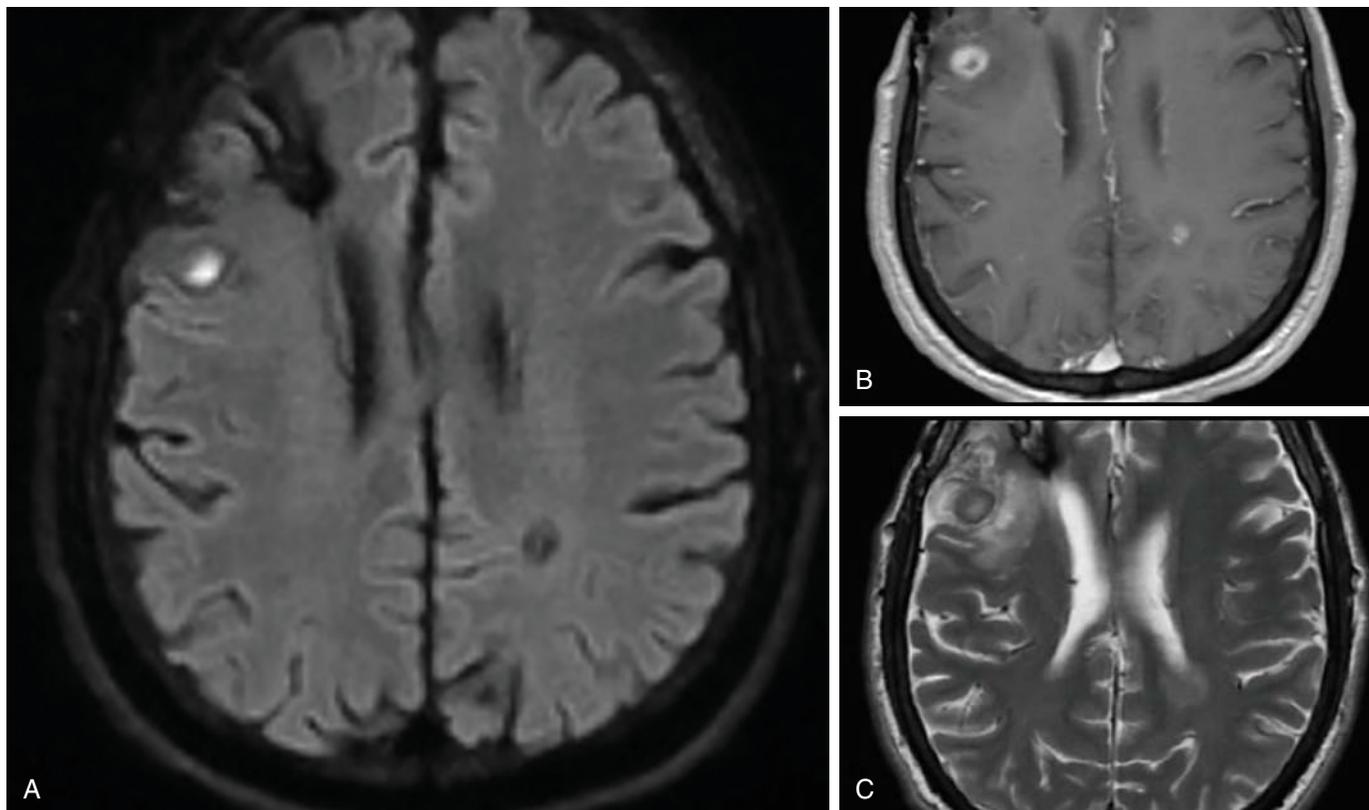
Cerebral abscess. A, Diffusion-weighted image shows a round lesion in the right frontal lobe with central hyperintensity representing restricted diffusion. Central diffusion restriction is a classic finding in cerebral abscess. B, T1-weighted MRI with contrast shows the abscess to demonstrate a pattern of peripheral contrast enhancement. C, T2-weighted MRI shows the characteristic hypointense rim of a cerebral abscess representing a fibrotic-like reaction. There is surrounding vasogenic edema related to blood–brain barrier disruption from the local inflammatory process.
